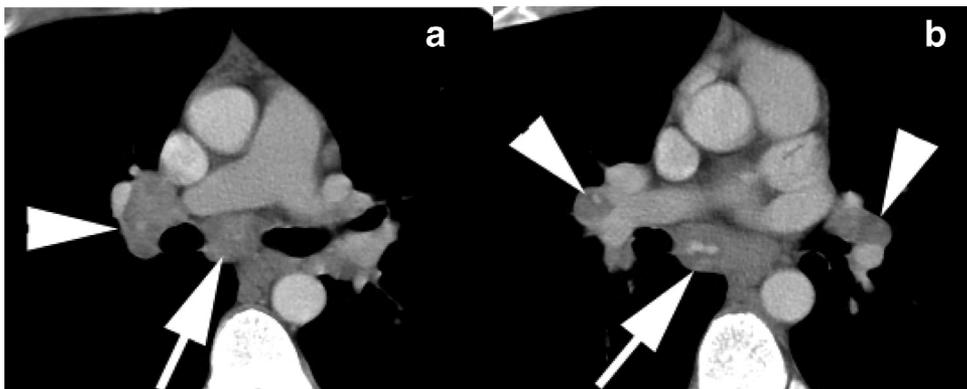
(a, b) CT showing symmetrical bilateral hilar (arrowheads) and mediastinal (arrows) lymphadenopathy with faint, amorphous calcifications. CT, computed tomography.
